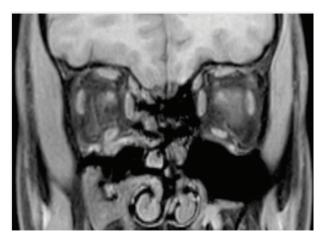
Magnetic resonance imaging scan – coronal slice.
